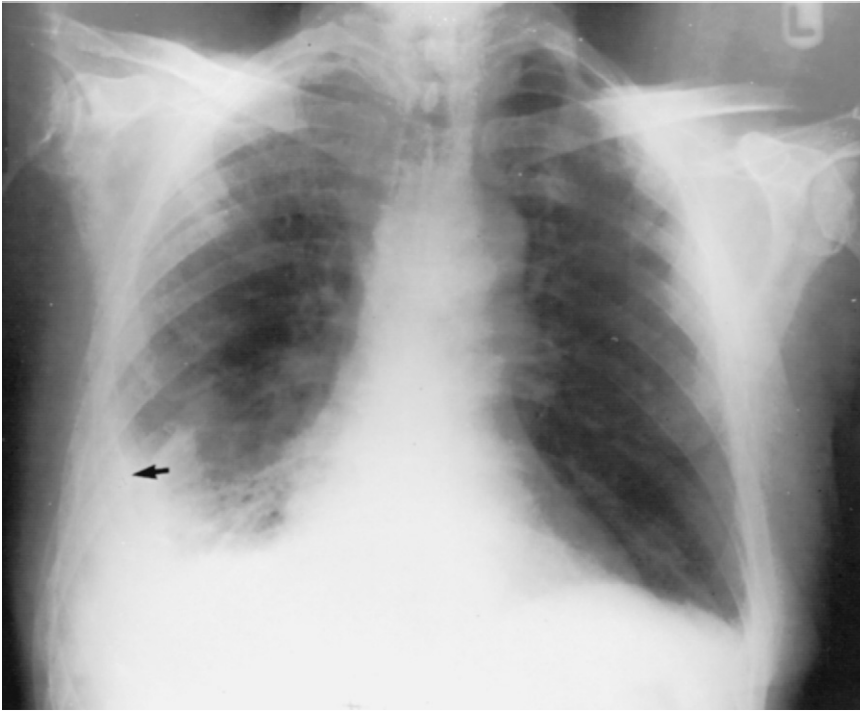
Chest radiograph of right lower lobe aspiration pneumonia. In addition to infiltrate at right base, note loculated pleural effusion, which represents empyema complicating pneumonia. Arrow points to edge of loculated effusion. (Courtesy Dr. T. Scott Johnson.)
